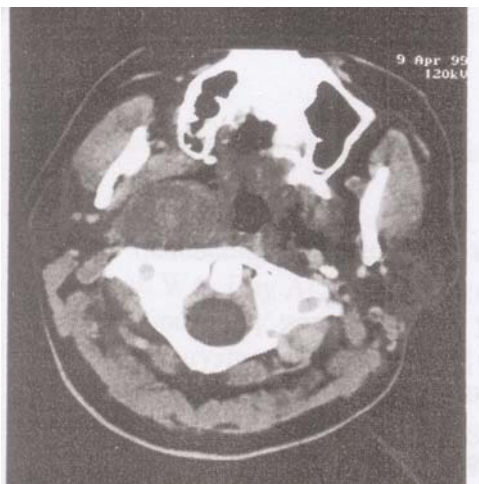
Non contrast head CT scan in axial plane showing well defined rounded mass involving right parapharyngeal space.
